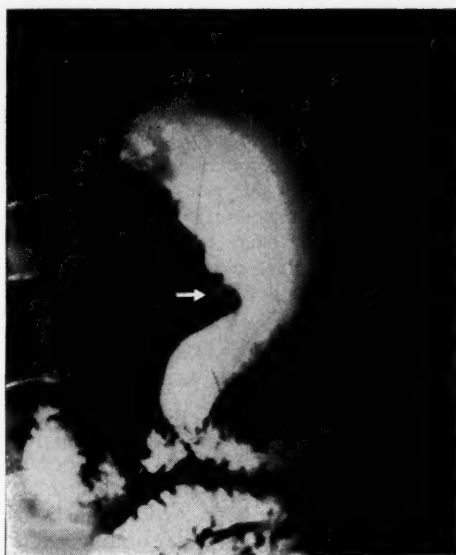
"Roentgen examination . . . revealed the ulcer to be very much in evidence."
